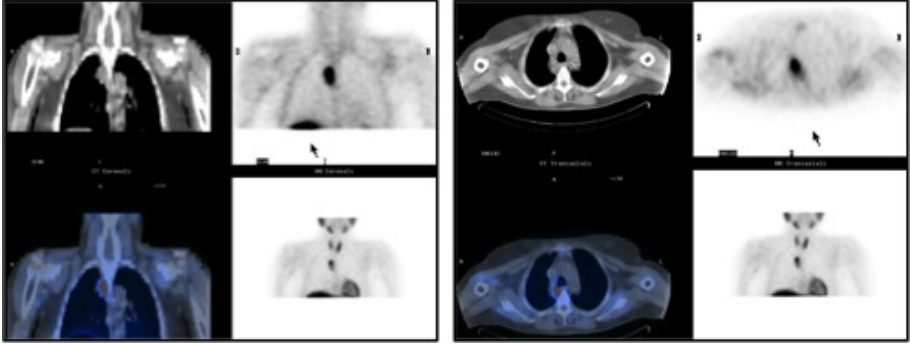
Technetium-99m sestamibi SPECT/CT images obtained of a patient with persistent primary hyperparathyroidism after prior unsuccessful parathyroid surgery. Coronal (left panel) and transaxial (right panel) SPECT/CT images demonstrate the presence of a large parathyroid adenoma located ectopically in the mediastinal space, right of the lower portion of the trachea just above its bifurcation. Lower right portions of both panels show the anterior MIPs of the head and chest.
